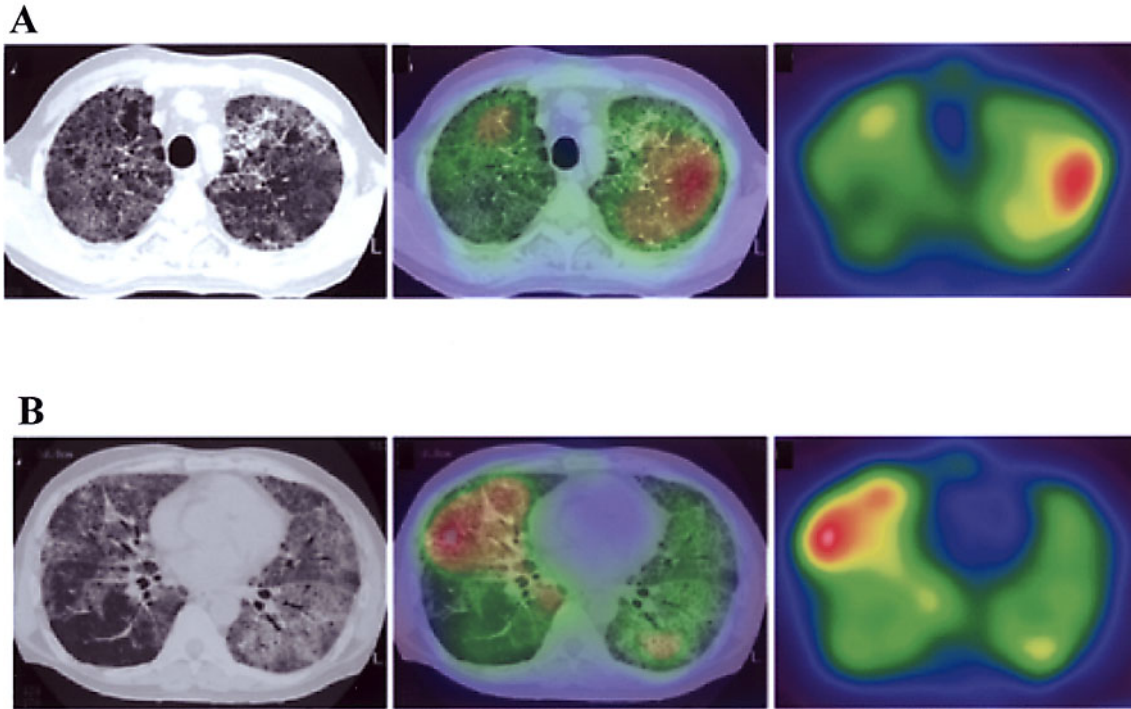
HRCT scan (*left panels*), ^{67}Ga -SPECT (*right panels*), and their superimposed images (*center panels*) on admission in both upper (A) and lower (B) lung fields. HRCT shows a geographic distribution of ground-glass opacities with thickened interlobular septa, so called "crazy paving." The accumulation of ^{67}Ga is strong in red, yellow, and green order.
